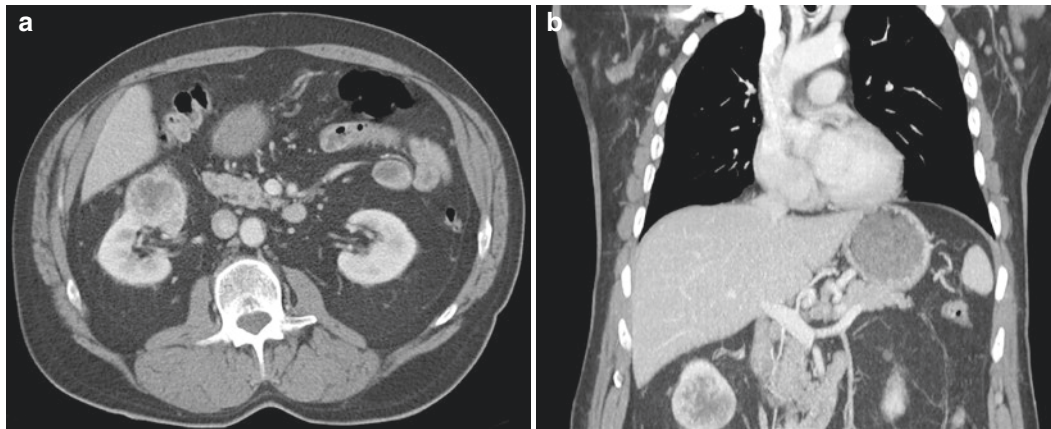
RCC, clear cell type, radioimages. (a) CT scan shows an exophytic mass arising from the inferior pole of the right kidney. There is evidence of central necrosis. (b) CT scan on coronal view, in which the mass appears to have a central region of necrosis
